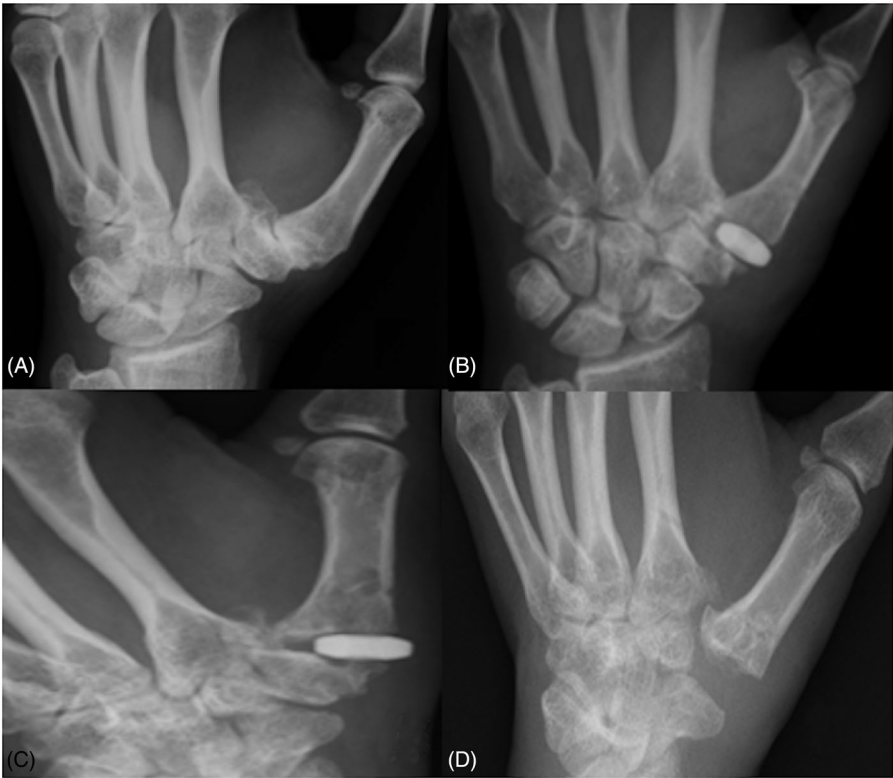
Pre-operative (A) and immediate post-operative (B) radiographs showing the positioning of the Pyrodisk implant in a 40 years old woman. Implant dislocation (C) occurred at 6 months and was successfully treated with the ablation of the implant and trapeziectomy with tendon interposition (D).
